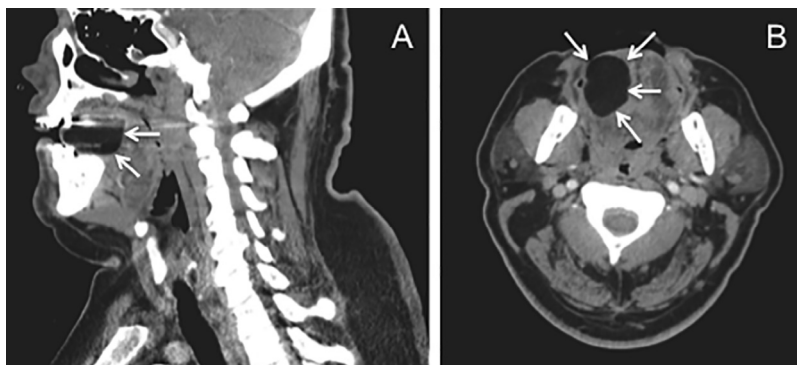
CT images of a 57-year-old male. (A) Sagittal and (B) axial scans demonstrating the large, low attenuation lipomatous mass (arrows) within the tongue. CT, computed tomography.
